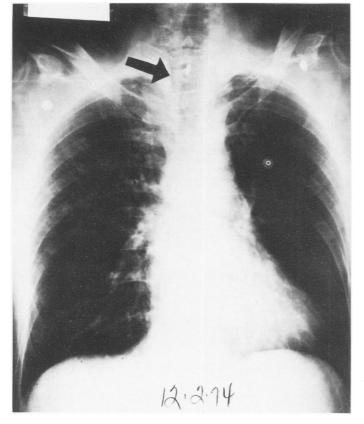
Case 1. The initial chest x-ray (PA) reveals only a pneumomediastinum without evidence of a pneumothorax or left pleural effusion.
